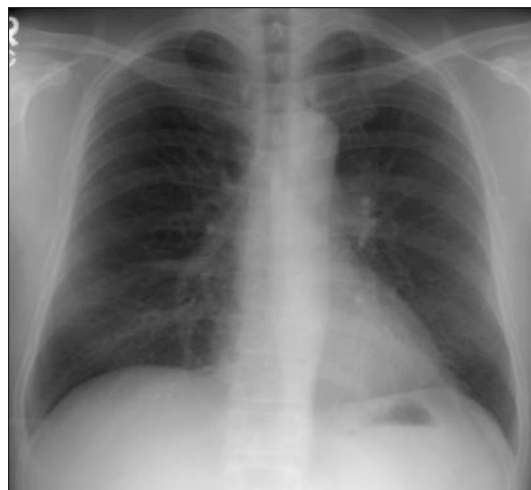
Chest X-ray film at the time of hypoxemia.
